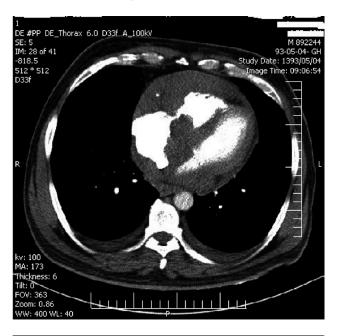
Extra-Cardiac and Intra-Cardiac Masses in Cardiac CT Angiography
